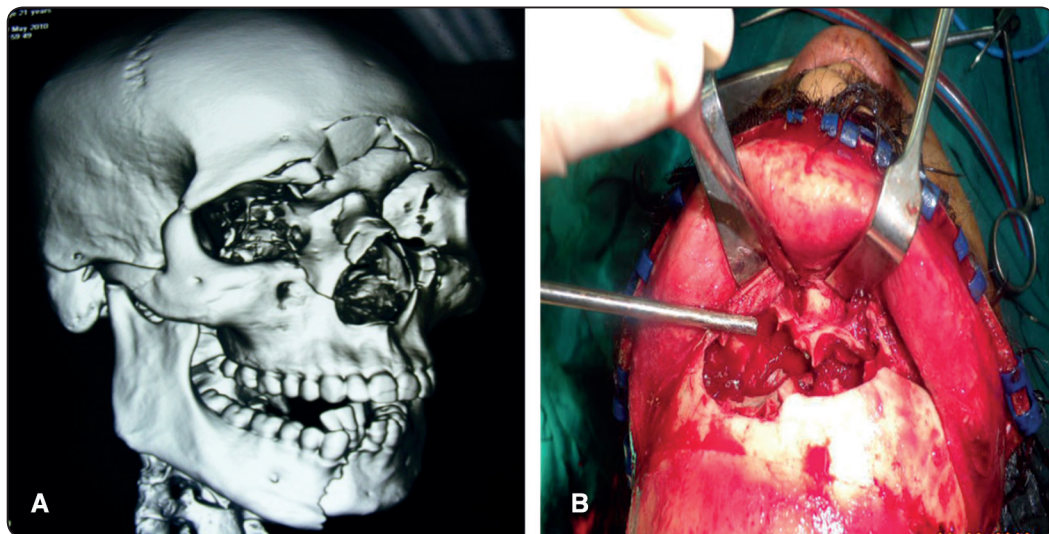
(A): Preoperative 3d CT scan showing frontal bone fracture (B): access to the FS via bicoronal flap
